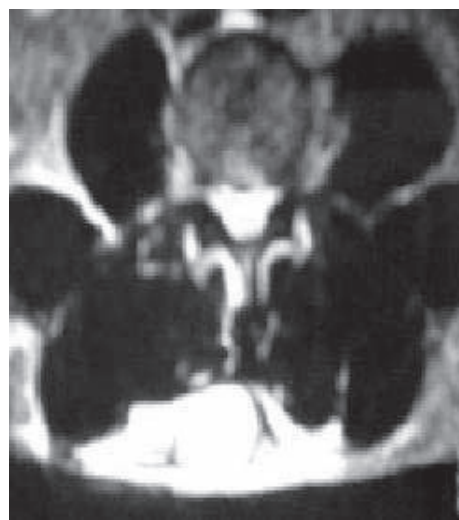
Axial MRI showing haematoma
